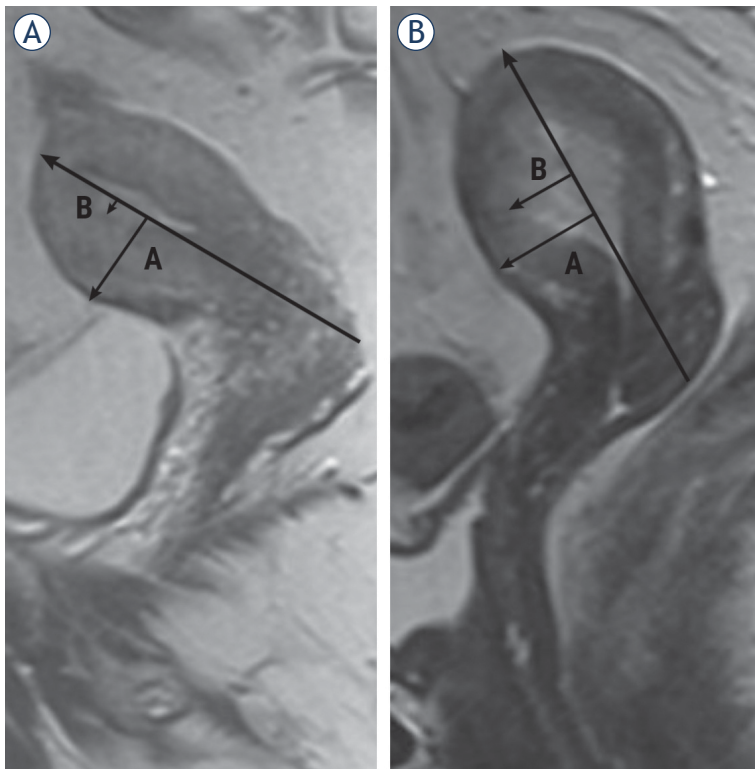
Assessment of myometrial invasion in patients with MRI, sagittal T2-weighted. Stage IA endometrial cancer in a 68-year-old postmenopausal woman, correctly diagnosed by TVUS and MRI. Arrow shows blurring of the junctional zone and the infiltration of superficial muscle (20%) (A). Stage IB endometrial cancer in a 58-year-old postmenopausal woman, correctly diagnosed by TVUS and MRI. Arrows refers to deep myometrial infiltration (60%) (B).
